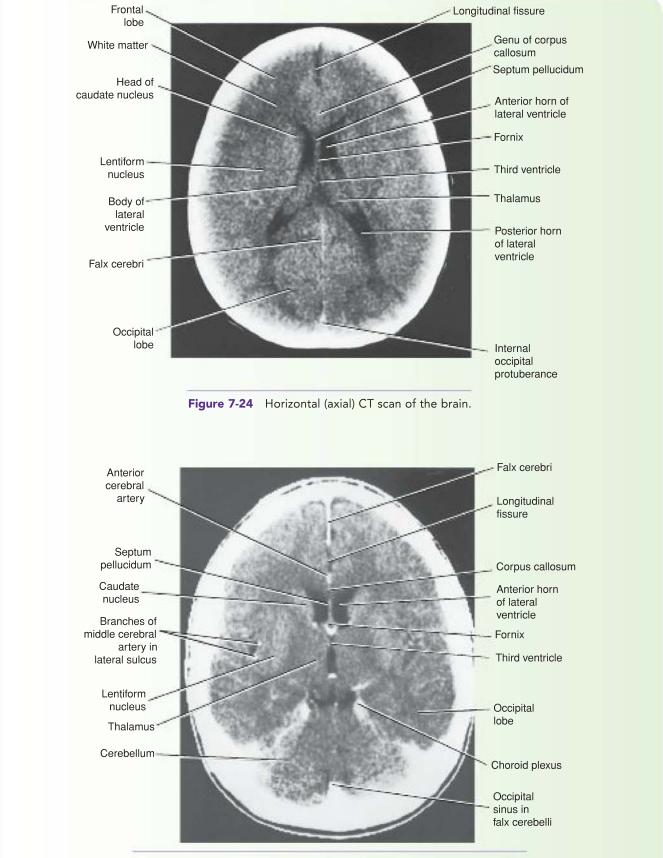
Horizontal (axial) CT scan of the brain (contrast enhanced).
